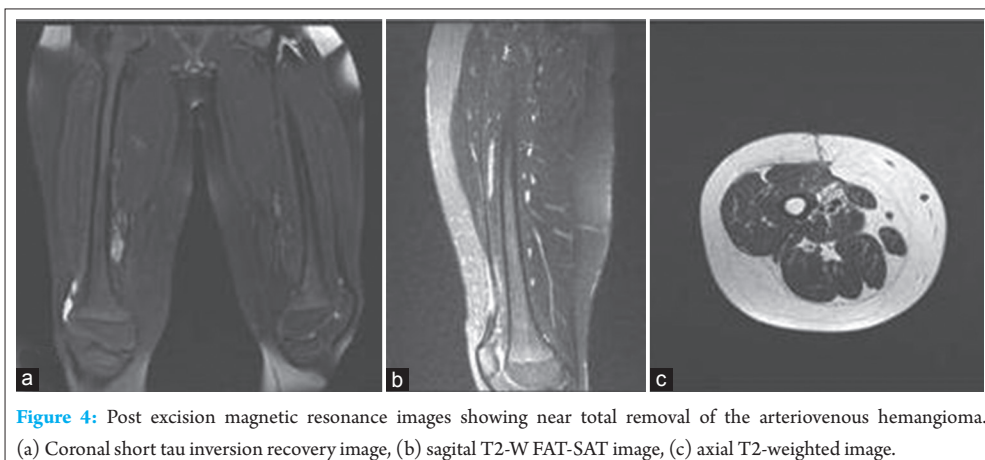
Post excision magnetic resonance images showing near total removal of the arteriovenous hemangioma. (a) Coronal short tau inversion recovery image, (b) sagittal T2-W FAT-SAT image, (c) axial T2-weighted image.
